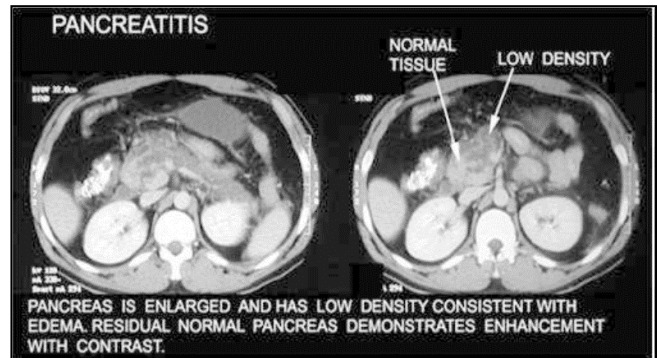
Contrast Enhanced Computed Tomography (CECT)
